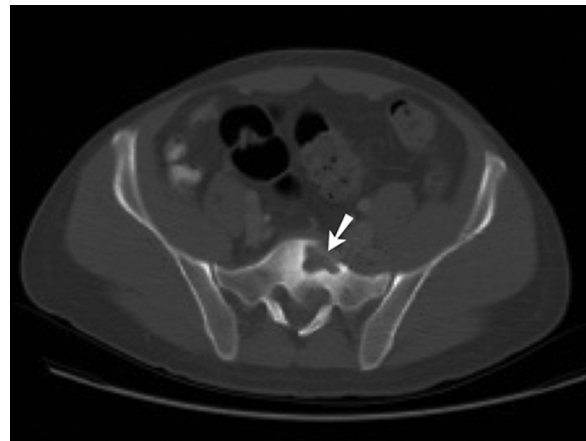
Axial CT scan image with bone windowing shows an expansile lytic lesion in the first sacral vertebra (arrow).
